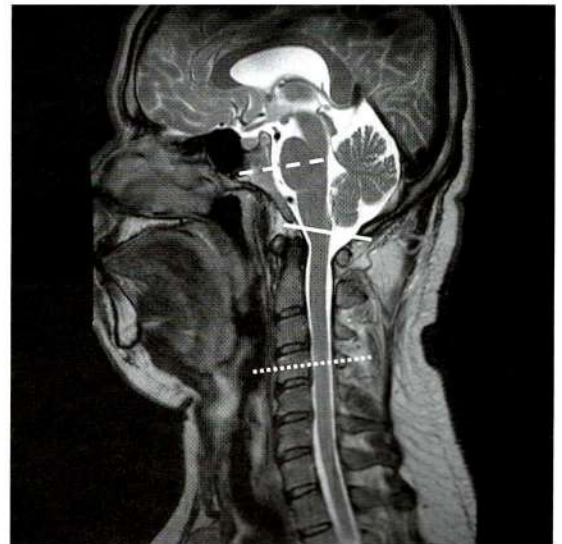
Axial planes are placed perpendicular to CSF space at the prepontine cistern, foramen magnum, and mid C5 levels (represented by dashed, solid, and dotted lines, respectively) on the T2-weighted images of a Chiari I patient (left) and of a healthy control volunteer (right).
